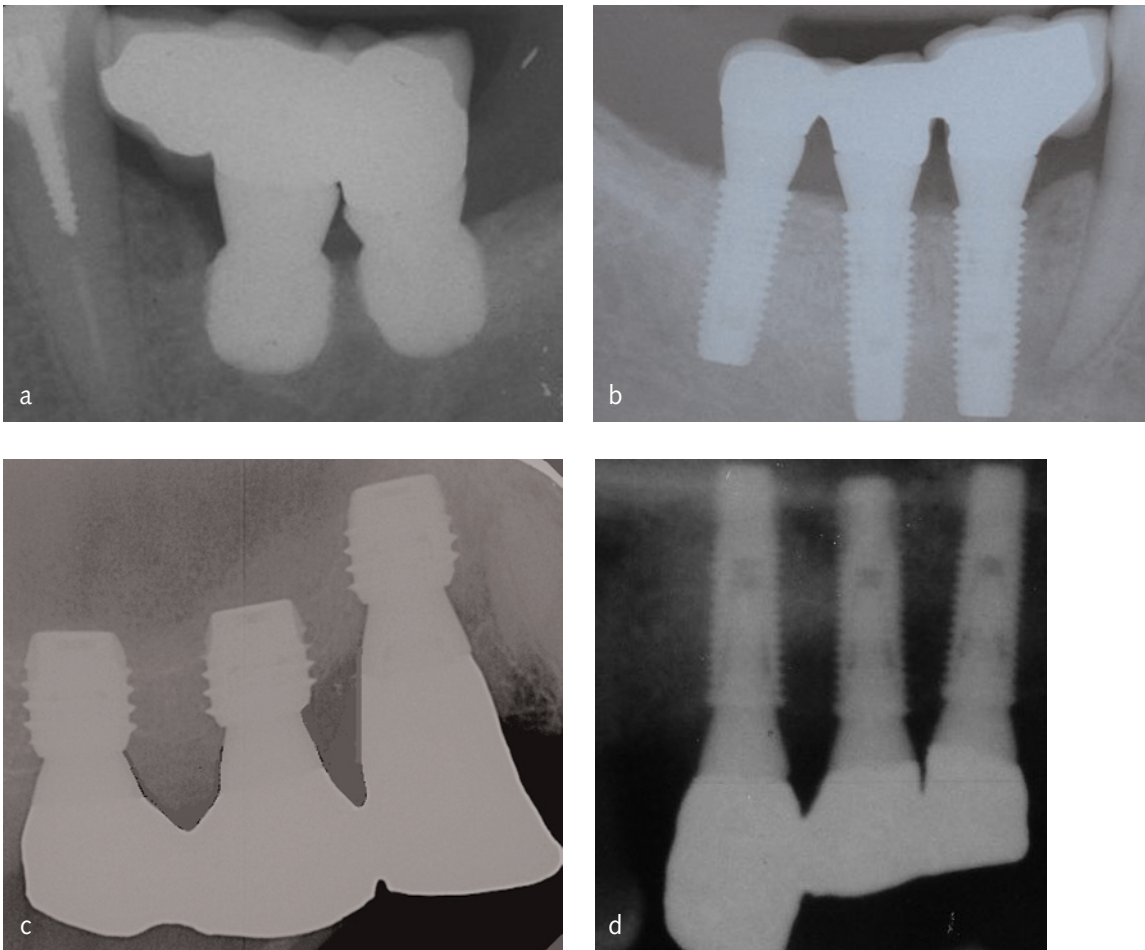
Intraoral radiographs of the study implants at delivery of the definitive restorations: a) short implants in mandible, b) long implants in augmented mandible, c) short maxillary implants and d) long implants in augmented sinus.
